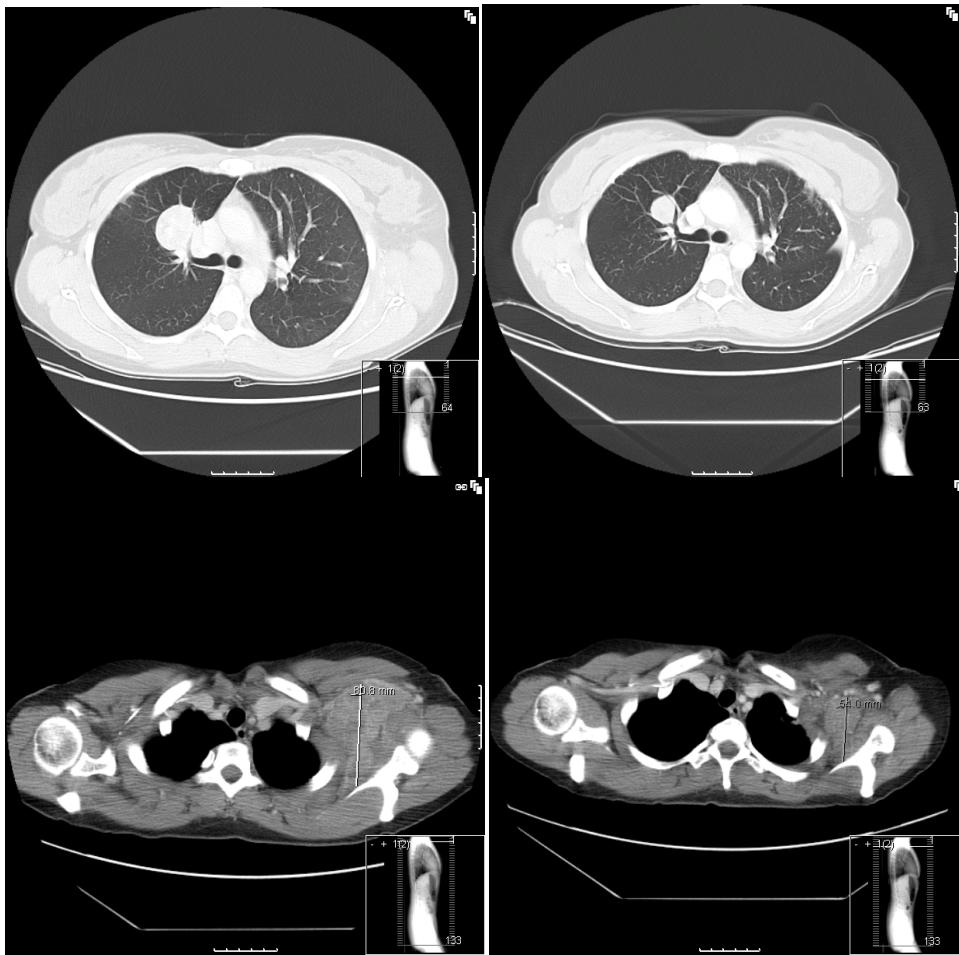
Pre- and post-treatment CT scans from a young woman with ASPS in the axilla and lungs treated with cediranib from August 2006 to June 2008.
